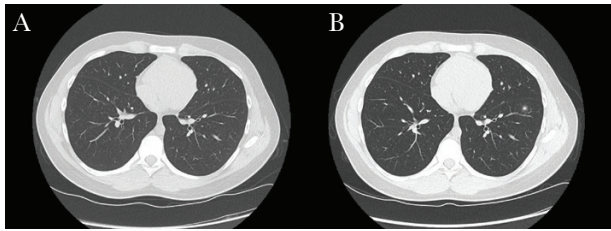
Radiographic comparison demonstrating a new-onset solitary lung nodule. A chest computed tomography scan demonstrated a new-onset 5-mm nodule in the anteromedial segment of the left lower lobe. A, February 2021. B, May 2021.
